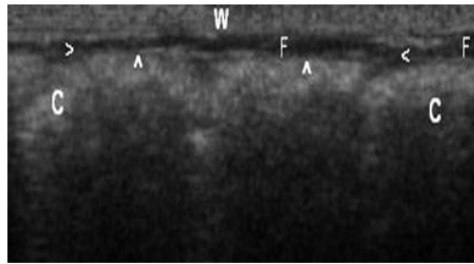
Transabdominal sonogram showed no adhesion between colon and abdominal wall (grade 0). (Group 2: Honey).
